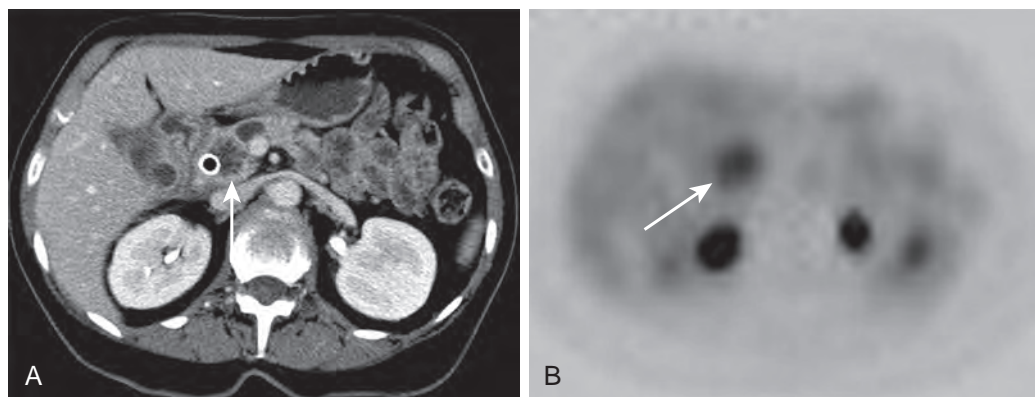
Pancreatic adenocarcinoma. A. Contrast-enhanced CT demonstrates a 2-cm mass in the head of the pancreas (arrow) with a stent in the adjacent common bile duct. B. PET demonstrates increased FDG avidity in the mass (arrow). Endoscopic biopsy confirmed pancreatic adenocarcinoma.
